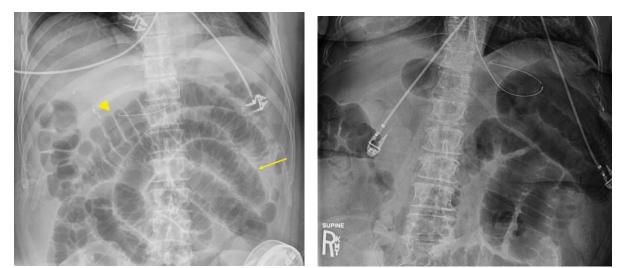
Postoperative ileus with (thin arrow) distended small bowel with plicae circulares and (large arrowhead) large bowel with haustra and Supine abdominal X-ray of small bowel obstruction: dilated small bowel and paucity of colonic gas.<sup>[4]</sup>
